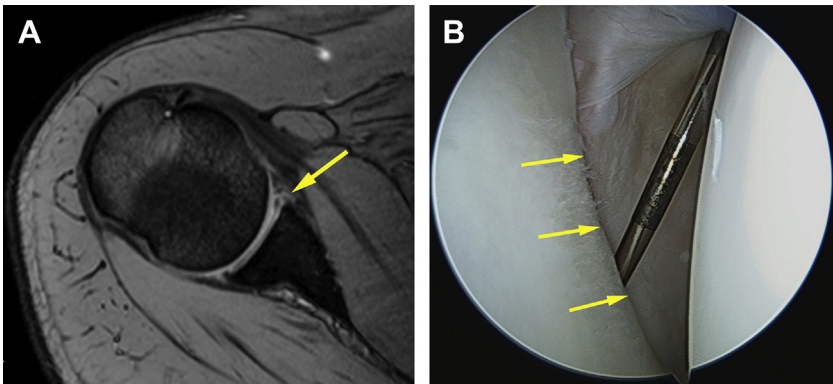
Magnetic resonance image showing disruption of the anteroinferior glenoid labrum (arrow, A). Arthroscopic image confirming discontinuity of the glenoid surface and redundant anterior labrum (arrows, B).
